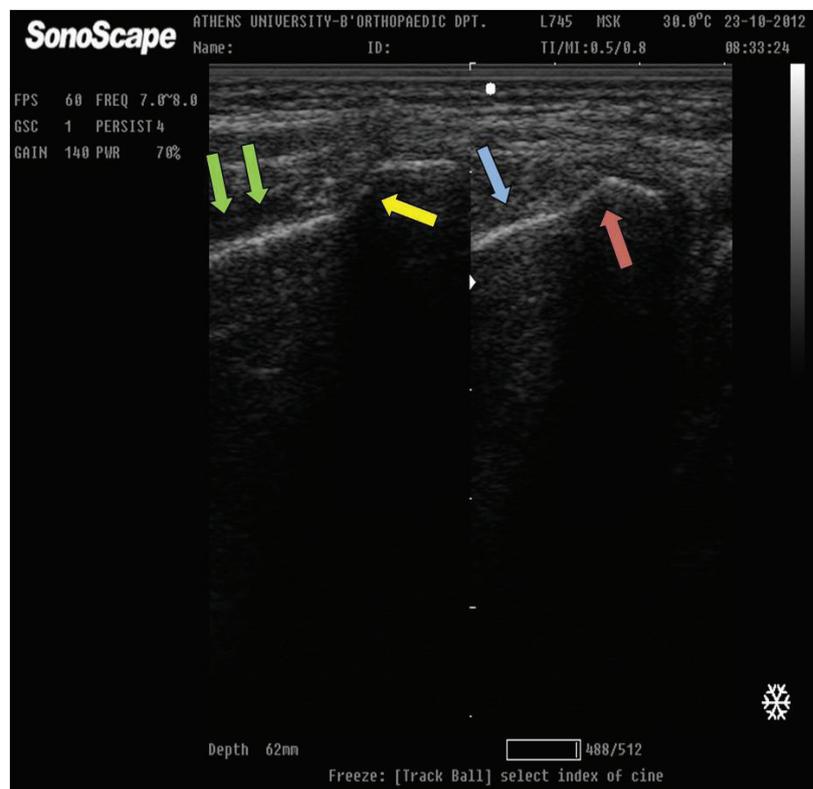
Comparative ultrasound image: Left: Clear cortical discontinuity in the radial head junction (yellow arrow) combined with subperiosteal hematoma (anechoic area) lying distally on the radius cortex (green arrows). Right: Normal radial head (purple arrow) and radial metaphysis without any hematoma (light blue arrow) in the contralateral elbow of the same patient.
